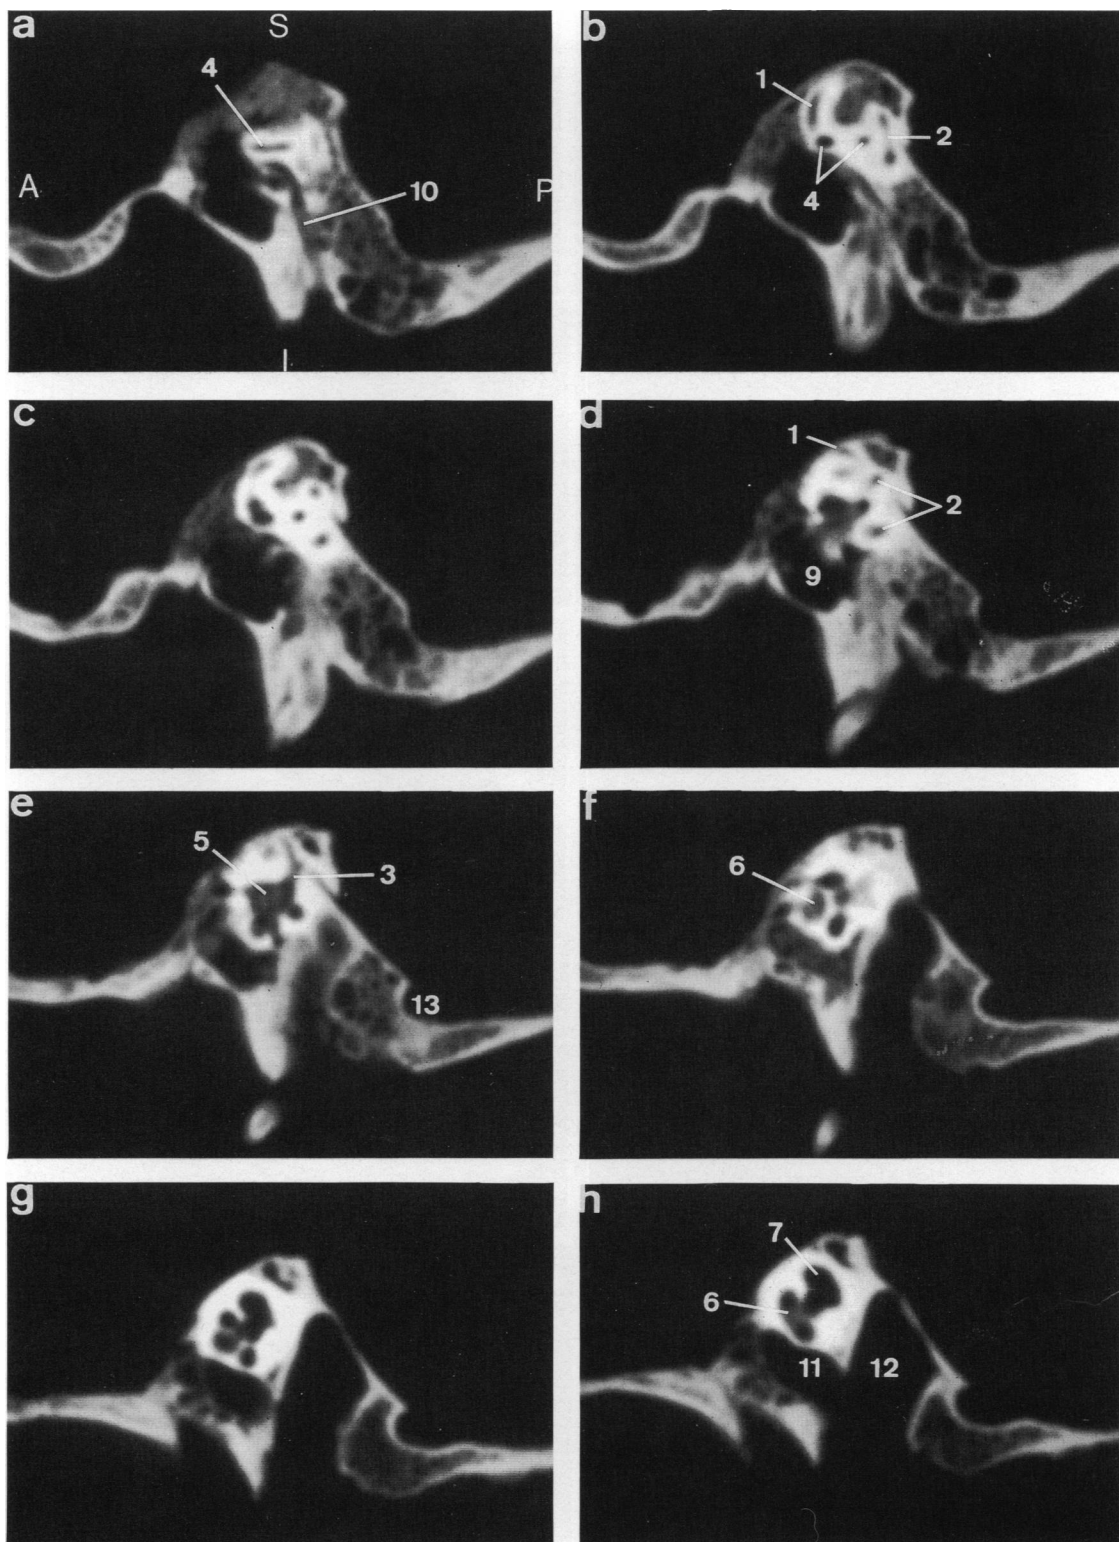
Contiguous sagittal CT scans of the temporal bone of a dry human skull going from lateral to medial, showing the labyrinth from the lateral tip of the lateral semicircular canal (a: 4) to the basal turn of the cochlea (h: 6). S, superior; I, inferior; A, anterior; P, posterior. 1, anterior semicircular canal; 2, posterior semicircular canal; 3, common crus; 4, lateral semicircular canal; 5, vestibule; 6, cochlea; 7, internal acoustic meatus; 9, tympanic cavity; 10, facial canal; 11, carotid canal; 12, jugular fossa; 13, sulcus for sigmoid sinus.
